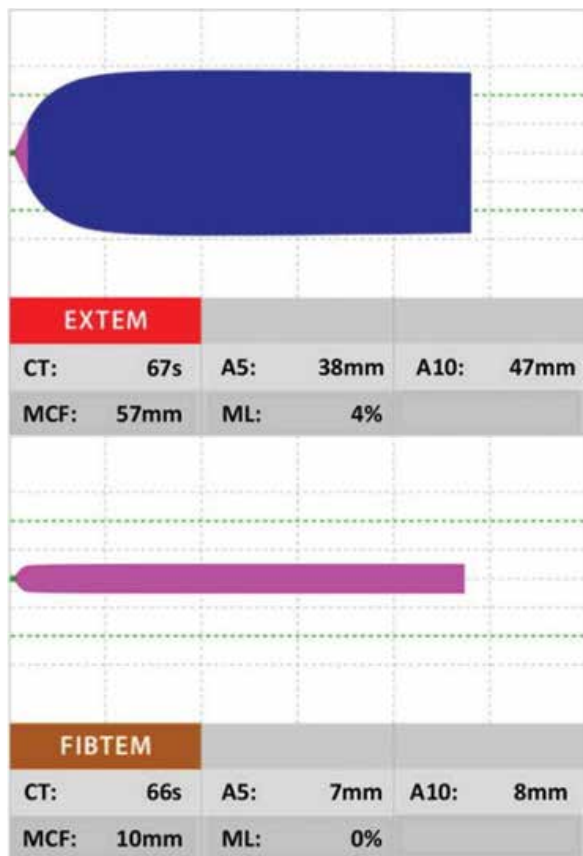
An example of normal coagulation as represented by the EXTEM and FIBTEM. The EXTEM show a normal coagulation activation (CT), normal clot formation (CFT and MCF) and a stable clot with minimal lysis. The FIBTEM shows a normal fibrin clot (A5 FIB 5-20mm) (Görlinger et al 2019). Reproduced with permission (CC BY 4.0).
